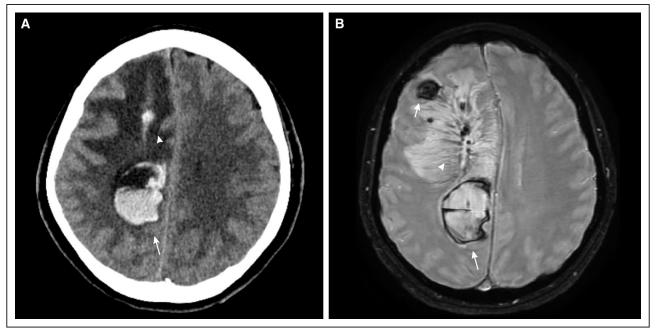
Axial head computed tomography (CT) and magnetic resonance imaging in a patient with seizures and COVID-19 infection.
